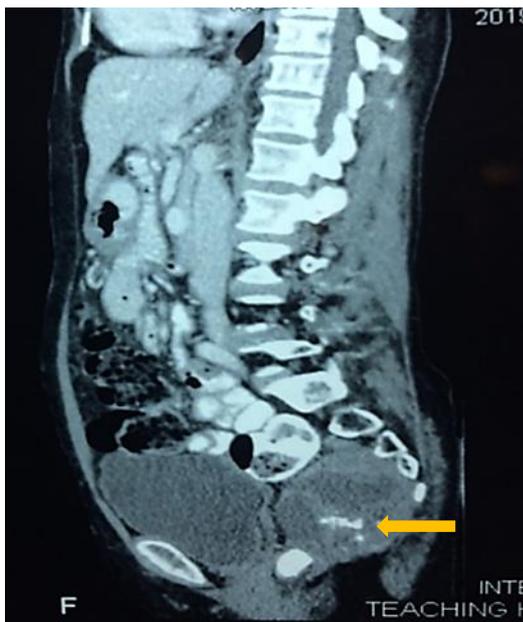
CT scan image of the tumour shows a solid and cystic lesion in the presacral region with calcifications (arrow).
